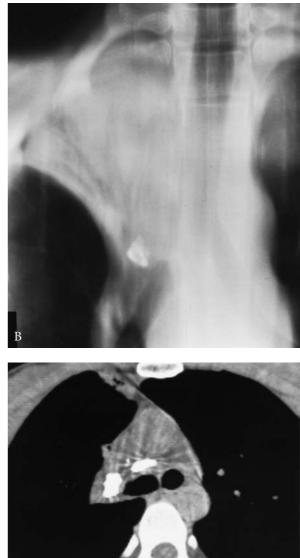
Tuberculous stenosis of the trachea and main bronchi, fibrotic stage. A, Chest radiograph reveals collapse of the left lung. Computed tomography scans reveal diffuse smooth stenosis of the trachea (B) and main bronchi (C). There is collapse of the left lung and a calcific left fibrothorax.
